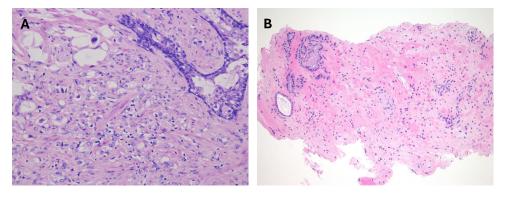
(A) Adenocarcinoma with radiation treatment effects. (B) Residual cancer adjacent to the high-intensity focused ultrasound-treated area.
